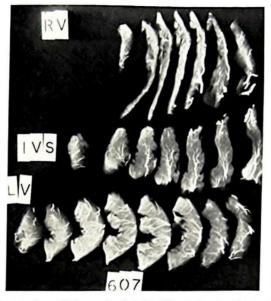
Radiographs of cut sections of the previously injected heart showing the terminal vessels within the myocardium and the anastomotic pattern. RV, Right ventricle; IVS, inter-ventricular septum and LV, left ventricle.
